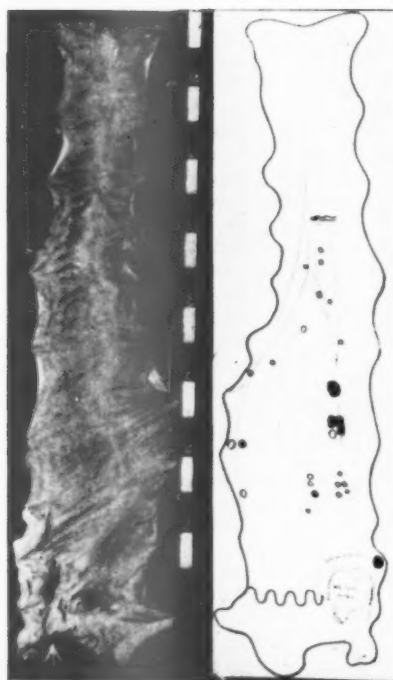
Four examples of anaplastic squamous cell carcinomas of the anal canal removed by radical combined excision. These were all C cases with lymph node involvement. Discontinuous lymphatic spread and also venous involvement are evident in D. The patient (A) had previously received deep X-ray therapy.
